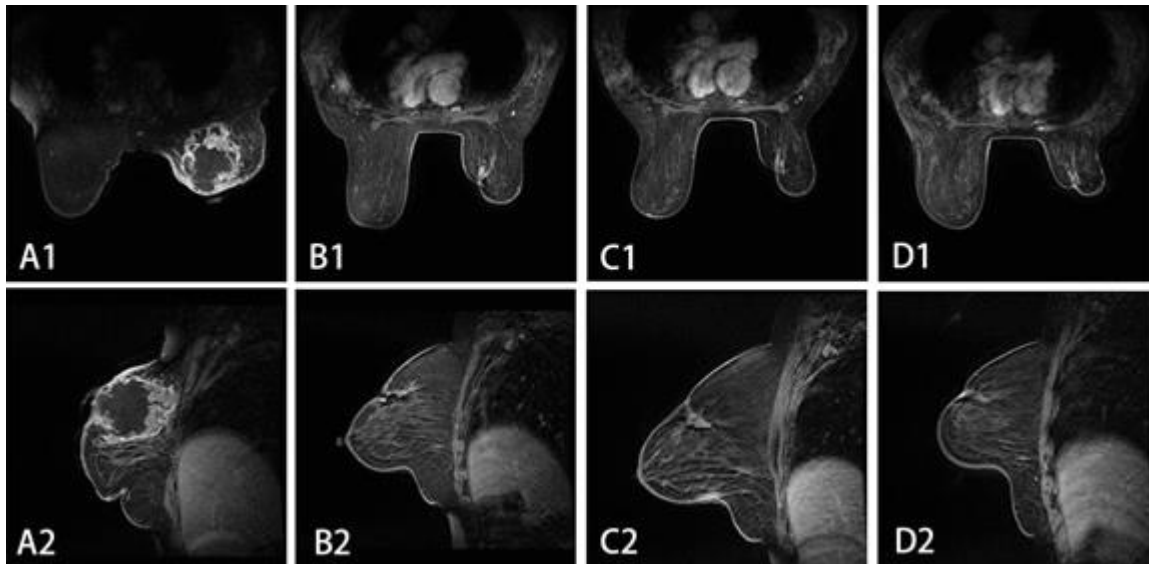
MRI showed the mass was considerably reduced after chemotherapy. A1-2: before chemotherapy, B1-2: 2 cycles, C1-2: 4 cycles, D1-2: 6 cycles.
